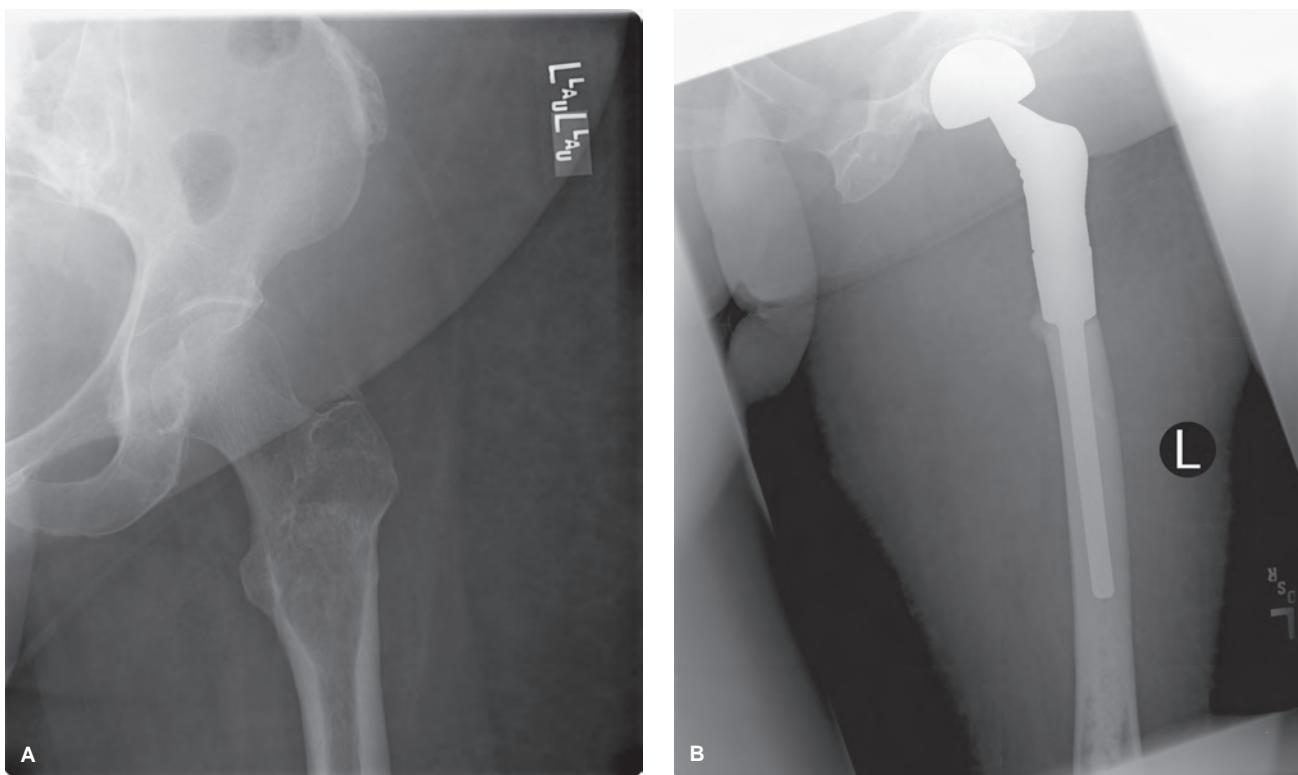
(A) Anteroposterior proximal femur in 60-year-old woman with metastatic breast cancer. Plain film shows disease in proximal femur extending into femoral neck and head. Patient had prior external beam therapy and presentation with 3-week history of debilitating groin pain and inability to walk. (B) Postoperative plain film shows long-stemmed hemiarthroplasty. Patient was able to return to ambulatory status prior to succumbing to disease 1 year later.
